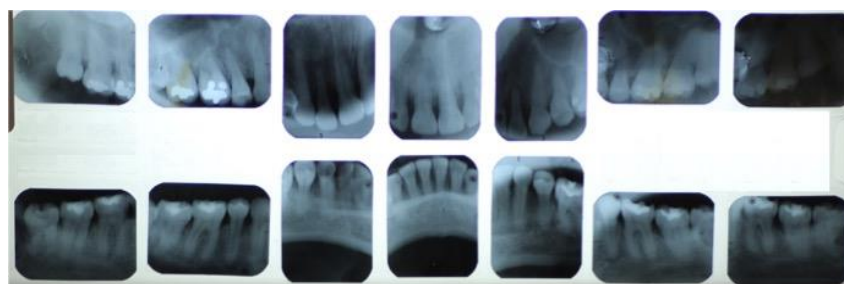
Periapical radiographs.
